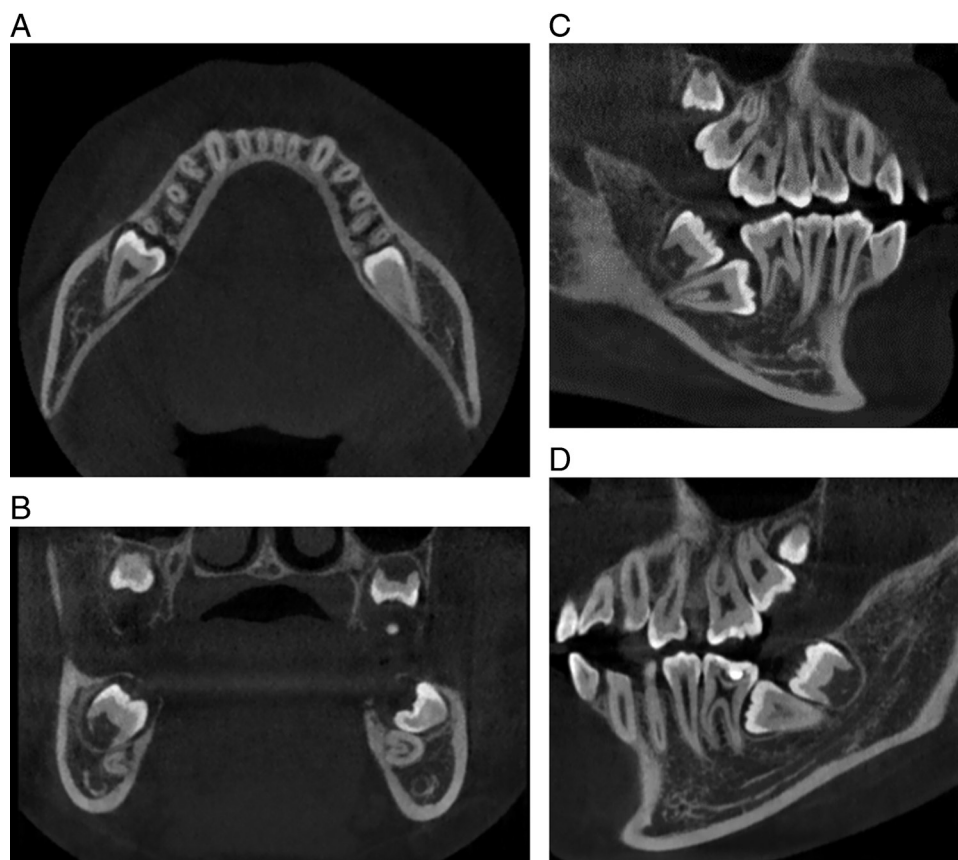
(A) Horizontal CT image of the bilateral Mdm2s before treatment. (B) Coronal CT image of the bilateral Mdm2s before treatment. (C) Sagittal CT images of the right Mdm2 before treatment. (D) Sagittal CT images of the left Mdm2 before treatment.
